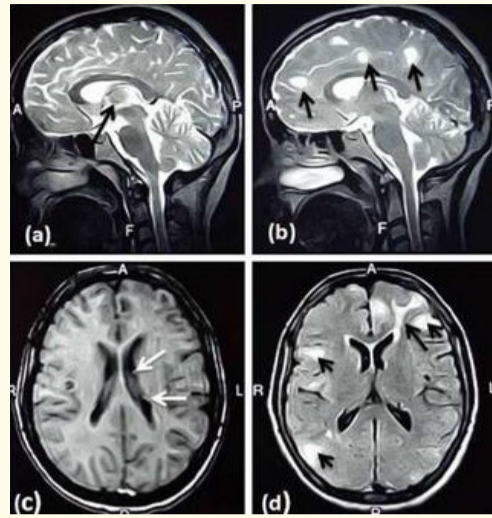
(a): Magnetic resonance imaging's can for the brain revealed giant cell astrocytomas in the right foramen of munro (black arrow). (b): Sagittal view of MRI showing dominant hyperintense lesion in the frontal cortex and subcortical region (black arrows). (c): Coronal view of MRI scan demonstrated multiple small subependymal nodules identified along the walls of lateral ventricle on left side (white arrows). (d): Coronal MRI scan revealed dominant hyperintense lesion in the left frontal cortex and subcortical region consistent with cortical tubers (small black arrows). Abnormal increasing signal extending from subependymal surface of ventricle through the left white matter of left side of frontal lobe which is continuous with the subcortical tuber of frontal lobe suggestive of radial glial band (long black arrow).
